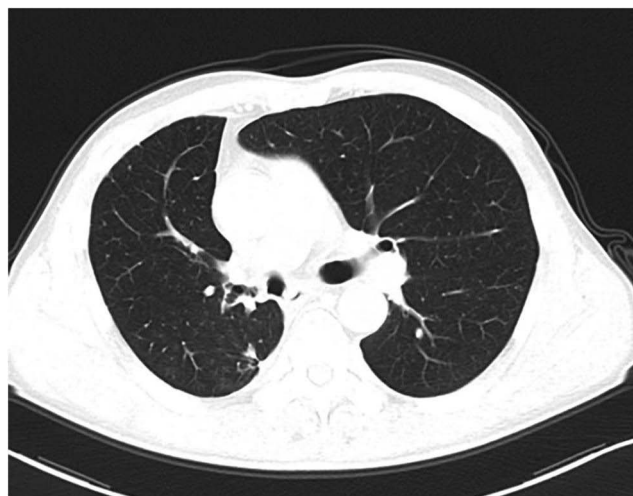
The latest CT examination.
